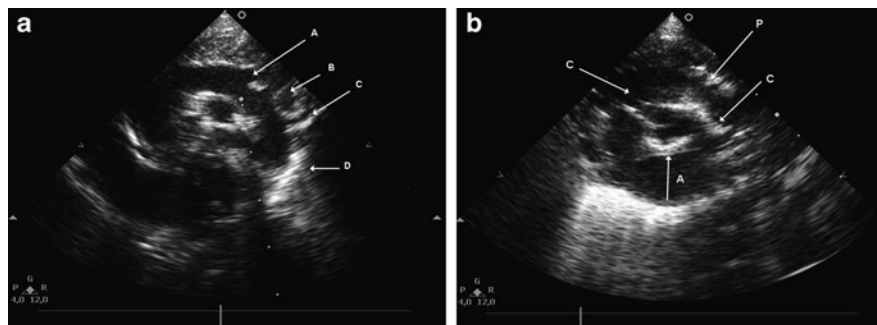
Echocardiographic manifestations of generalized arterial calcification of infancy. *Panel A:* Echocardiogram at 1 month of life (upper-sternal axis view). Note the calcification of the aortic arch, descending aorta (D) and of the supraaortic vessels: brachiocephalic trunk (A), left carotid artery (B), left subclavian artery (C). *Panel B:* Echocardiogram at 1 month of life (parasternal short axis view). Note the hyperechogenicity of the pulmonary (P) and aortic (A) anulus and of the coronary arteries (C)
